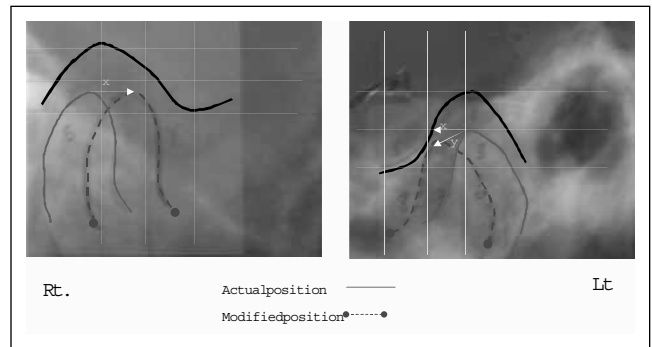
Repositioning of the condyles on the transcranial radiograph.
